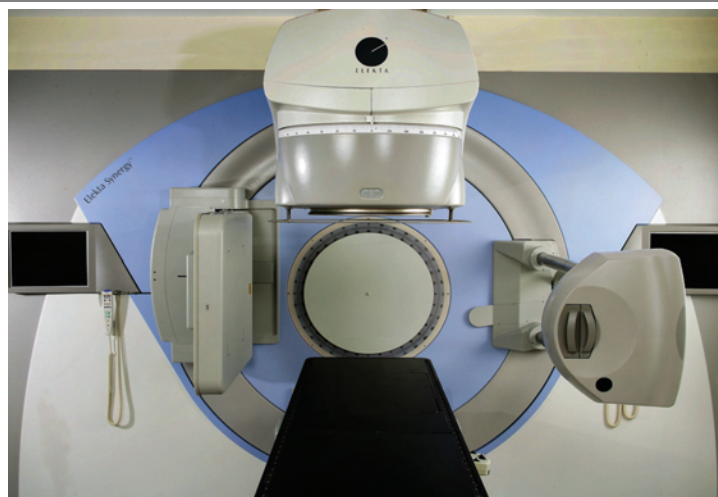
The Elekta Synergy linac with on board kv cone-beam system.
